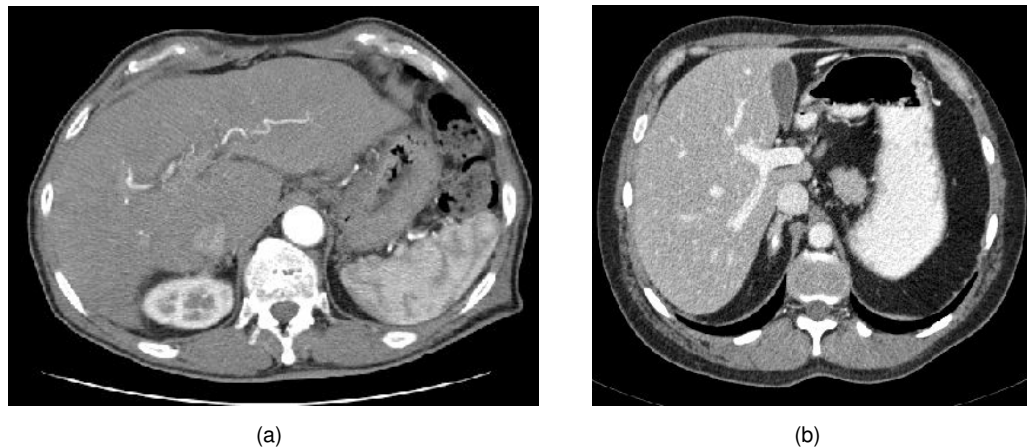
Two commonly used CT contrast enhancement phases: (a) arterial phase, (b) portal-venous phase.
